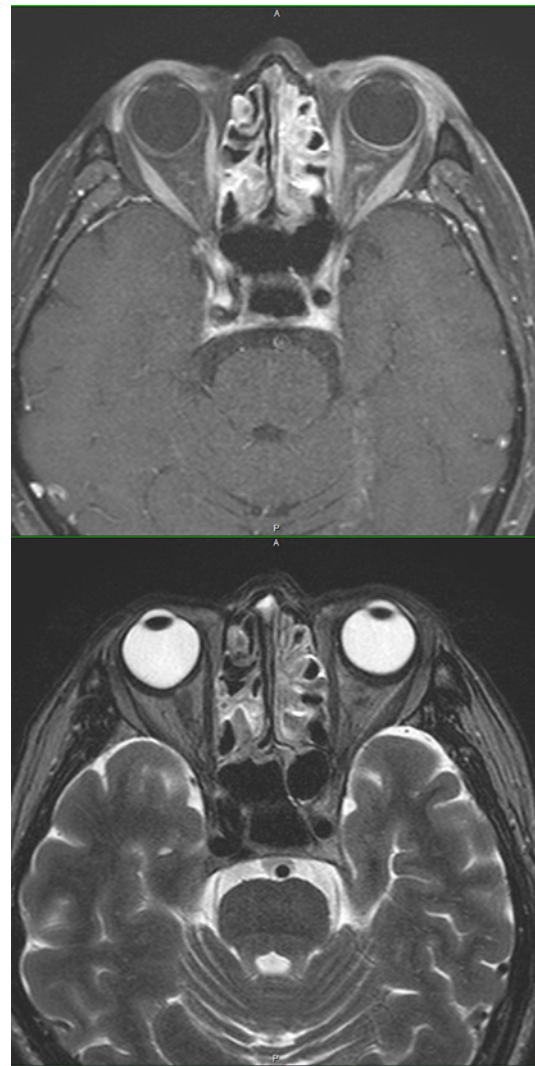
Magnetic resonance imaging revealed a subtle enhancement in the T1 phase with gadolinium (upper figure) and hypersignal T2 (lower figure) of the left cavernous sinus in the axial section.
